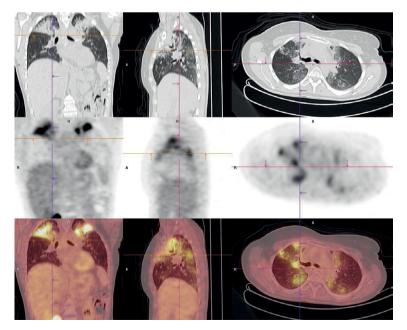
PET-CT patient1: Suspicious relapse in pulmonal tissue.
